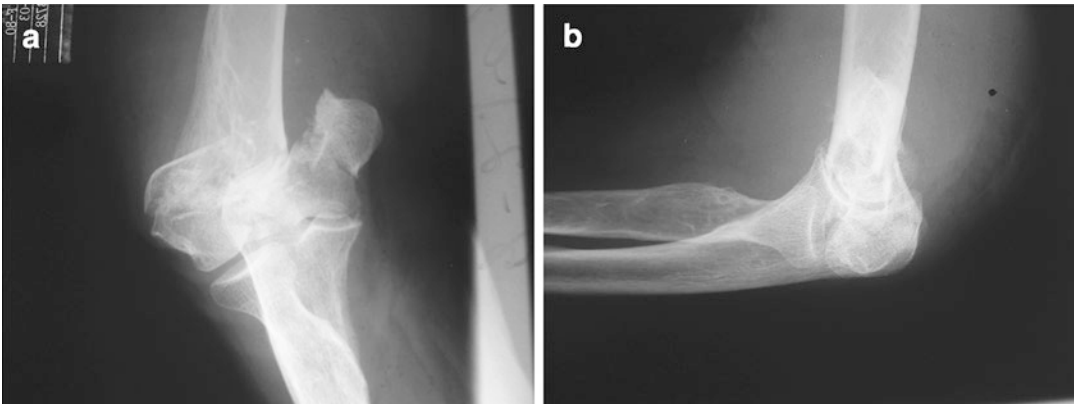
(a) AP radiograph elbow. (b) Lateral radiograph elbow (Copyright © retained by authors)
